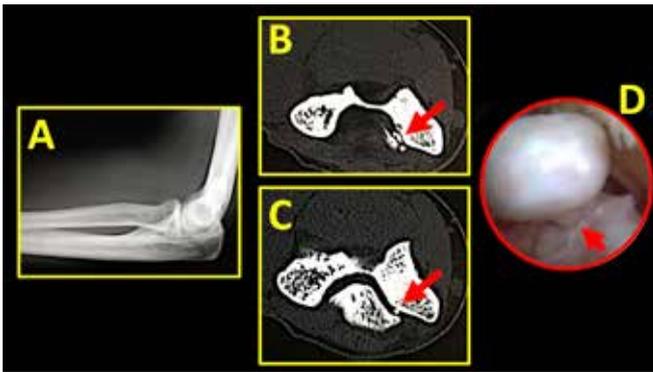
Intra-articular snapping of the elbow due to intra-articular free bodies. Lateral (A) elbow radiographs and CT axial images in (B) and (C) respectively, showing intra-articular free bodies. (D) Arthroscopic image of intra-articular free bodies.
